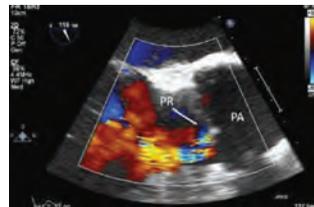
This 2D colored doppler TEE image shows pulmonary regurgitation.
